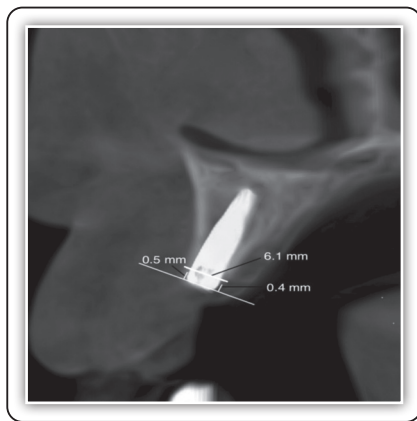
Cone beam CT after 2 months postoperatively showing horizontal bone width of 6.1 mm and decrease in labial crestal bone height by 0.5 mm and decrease in palatal crestal bone height by 0.4 mm
